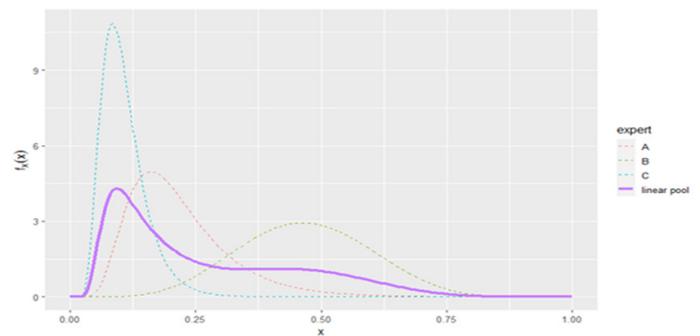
The fitted consensus distributions (proportion of patients undergoing brain CT scan) and the fitted probabilities.
